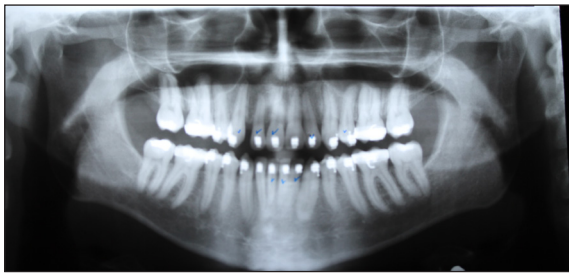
A) Pre de-bracketing, frontal view; B) Pre de-bracketing, lateral view; C) Pre de-bracketing, posed smile; D) Pre de-bracketing, panoramic radiogram; E) Pre de-bracketing, lips reposed; F) Pre de-bracketing, posed smile; G) Pre de-bracketing, right lateral view; H) Pre de-bracketing, frontal view; I) Pre de-bracketing, left lateral view
